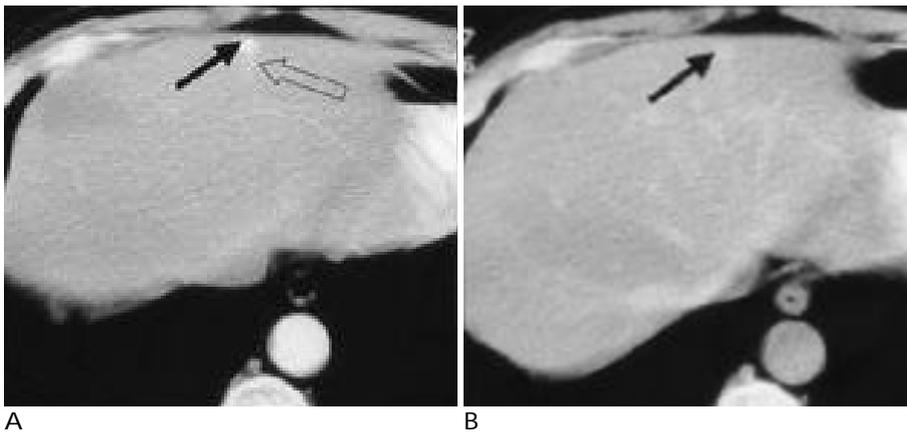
CT scans obtained in a 47-year-old man with hemangioma.
